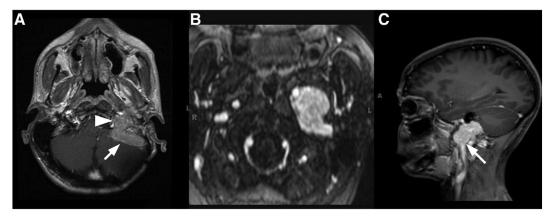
(A) MRI (T1WI with contrast) of a jugular foramen paraganglioma (arrowhead) with JV invasion up to and including the sigmoid sinus (arrows). (B) Glomus vagale with surgical proof of JV invasion. (C) Contrast-enhanced sagittal T1WI shows growth of a GJ into the JV (arrow).
